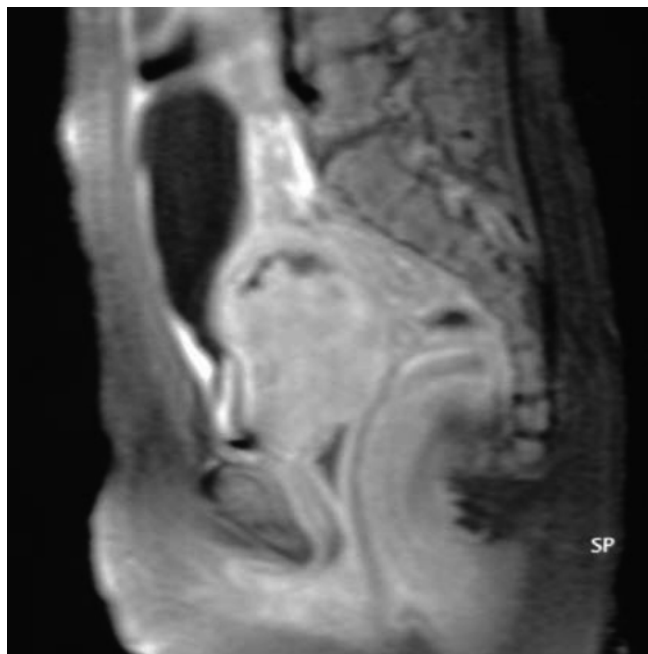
Vitellin tumour of the upper third of the vagina (sagittal T1 weighted MRI)
